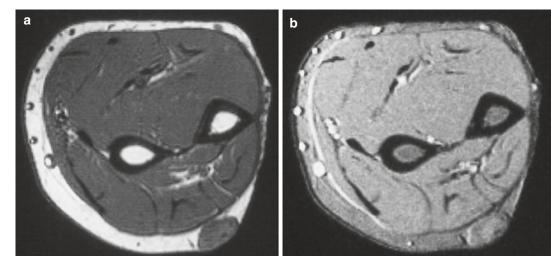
A 60-year-old man with a subcutaneous lesion in the left lower arm: (a) axial spin echo T1-weighted MR image; (b) axial gradient echo T2-weighted MR image.
